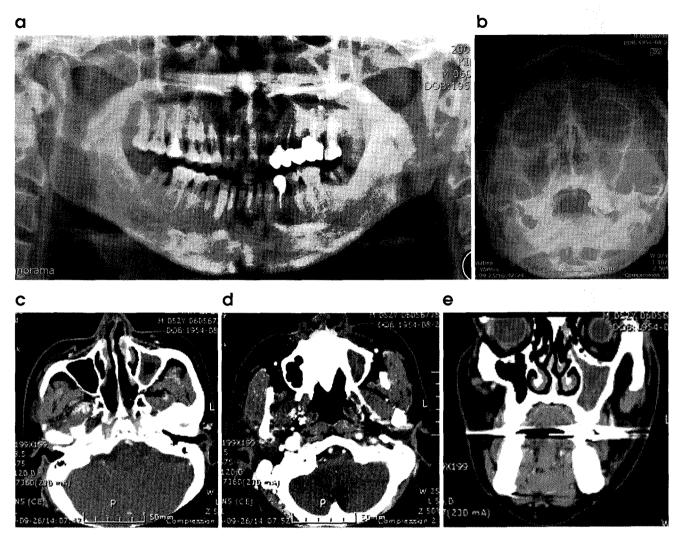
(a) Left maxillary sinusitis with upper and lower radiopacity in panoramic view; (b) Left maxillary sinusitis with increased radiopacity in Waters' view; (c), (d), (e) Left maxillary sinusitis with increased radiopacity in CT.
